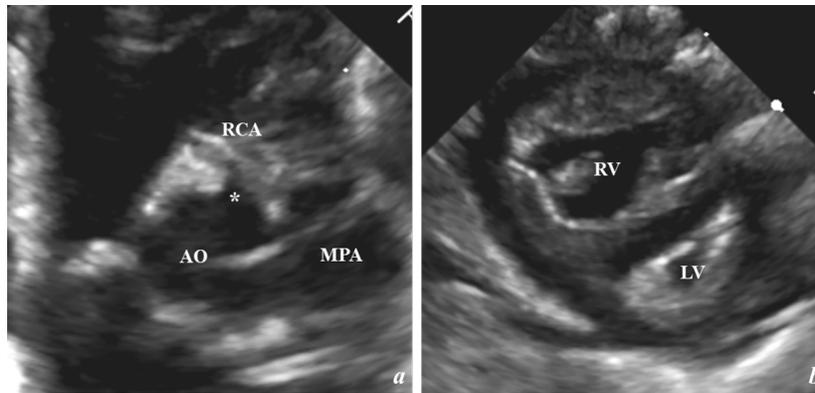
a. The «apparently normal» origin (*) of the RCA from the anterior aortic rightward sinus of Valsalva, a common pitfall in echocardiographic screening of coronary arteries; b. RV dilation and D-shaped LV due to the leftward shift of the interventricular septum for the high pulmonary pressures of the newborn at arrival.
